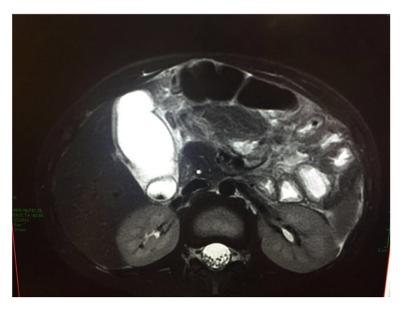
T2 weighted sequence in MRI cholangiography showing gallbladder hematoma with peritoneal fluid around the gallbladder.
